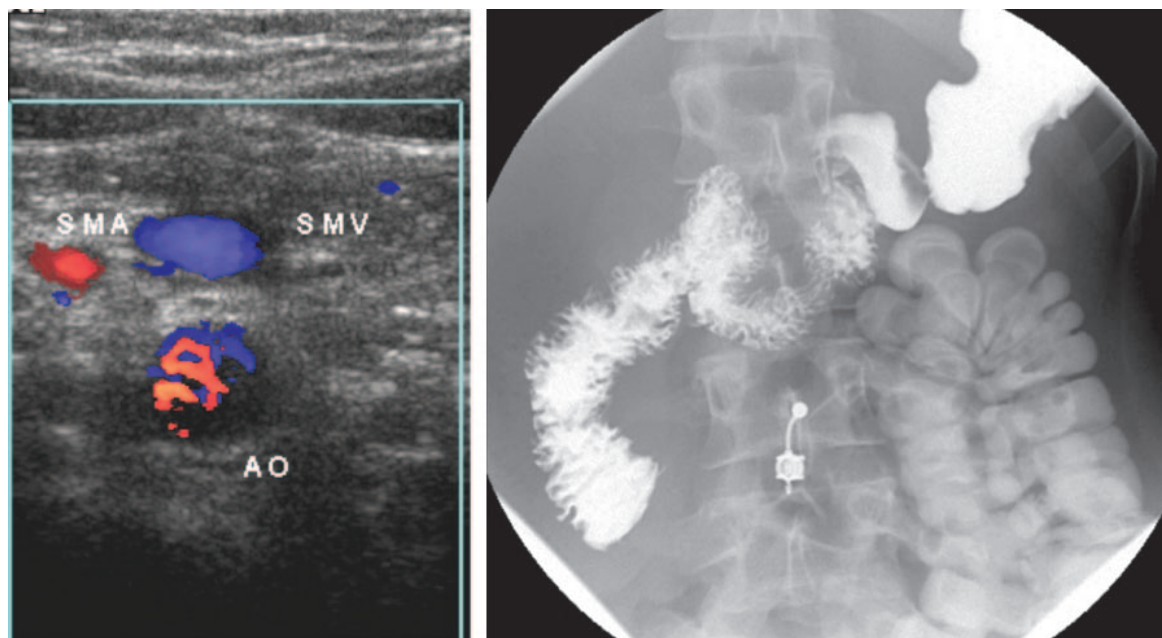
Malrotation in a 16-year-old girl with intermittent abdominal pain. (a) Transverse sonogram shows the reversal of the normal anatomic relation of the superior mesenteric artery (*SMA*) and superior mesenteric vein (*SMV*), a finding that prompted the radiologist to request an upper GI series. *AO* = aorta. (b) Fluoroscopic image shows an abnormal course of the duodenum into the right side of the abdomen. The colon, which is located in the left side of the abdomen, contains contrast material from an earlier CT examination. The patient underwent a Ladd procedure, which was successful.
